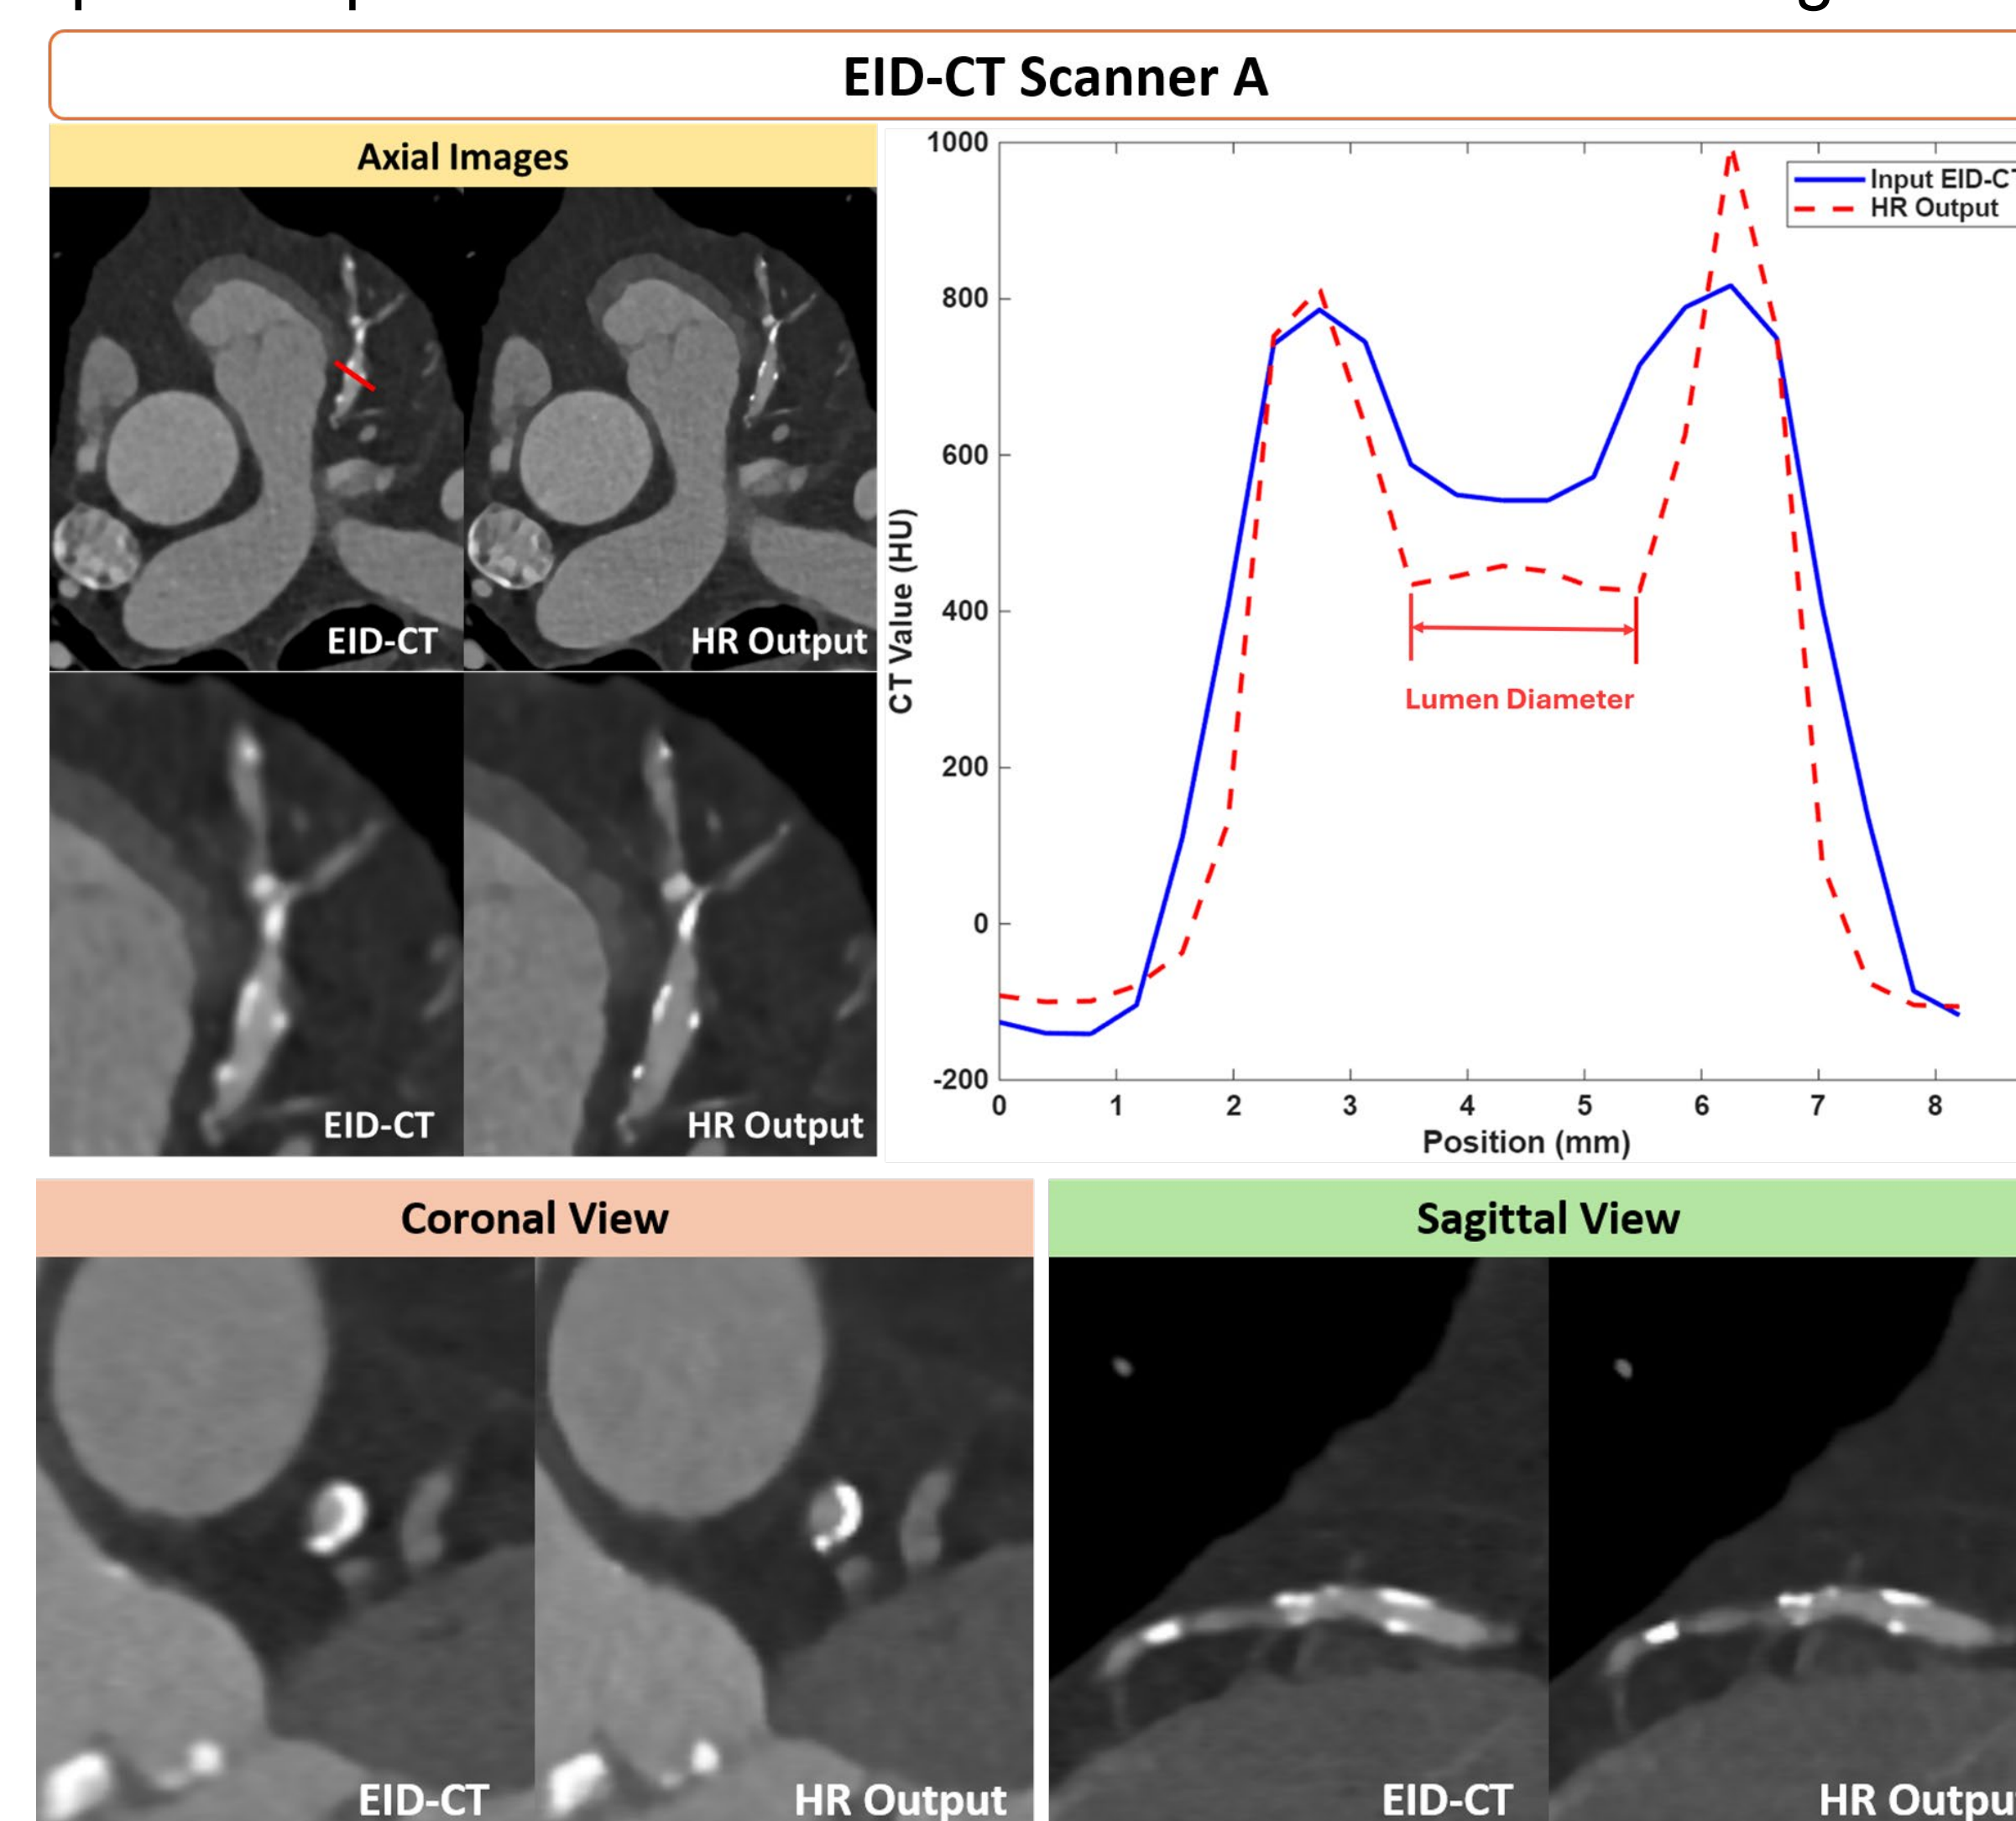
Representative case from a Force Scanner. The HR output shows improved sharpness and clearer vessel boundaries across all dimensions compared with input EID-CT. The line profile across coronary calcification demonstrates steeper intensity transitions and increased apparent lumen diameter. Images are displayed at WW/WL = 1500/400 HU.
